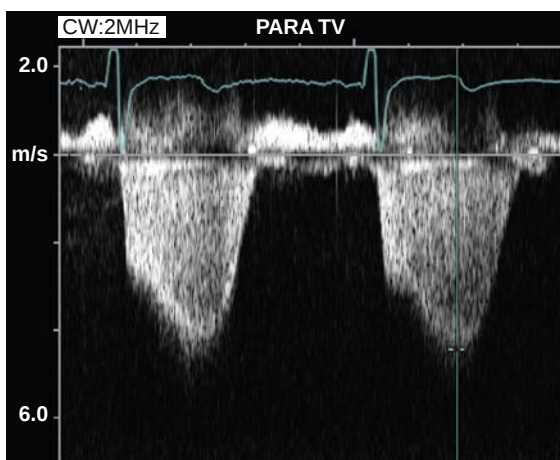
Tricuspid regurgitant (TR) jet velocity. The tricuspid regurgitation jet is recorded with CW Doppler from both the parasternal RV inflow view and from the LV apex. Only the highest velocity is reported, in normal sinus rhythm, because the apparent lower velocity signal is due to a nonparallel intercept angle between the ultrasound beam and regurgitant jet. This example shows a high velocity jet consistent with severe pulmonary hypertension. The maximum velocity is measured at the edge of the dense “envelope” of flow, avoiding the faint signals due to gain and transit time effects.
